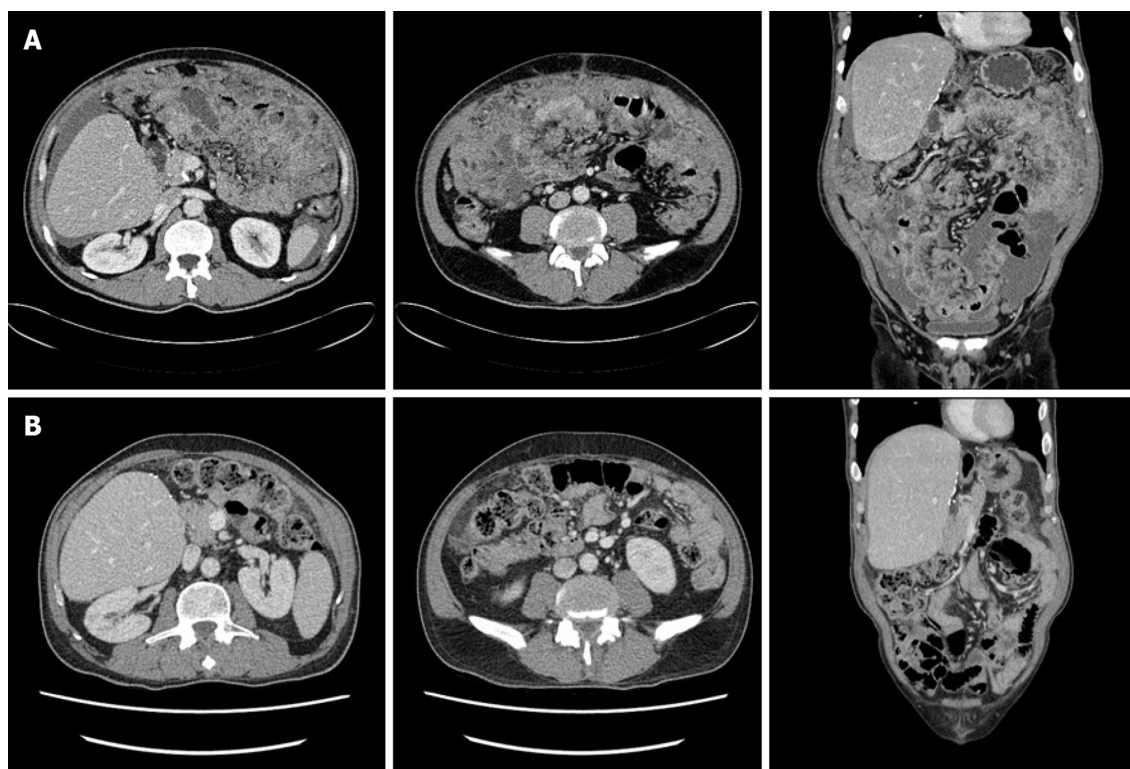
Abdominopelvic computed tomography. A: Computed tomography (CT) depicting a large volume of ascites and diffuse peritoneal infiltrative lesions at the mesentery and omentum, but no mass-like lesions in the gastrointestinal tract and no bowel obstruction; B: Post-chemotherapy CT depicting no signs of omental mass or ascites, but mild haziness in the omental fat.
